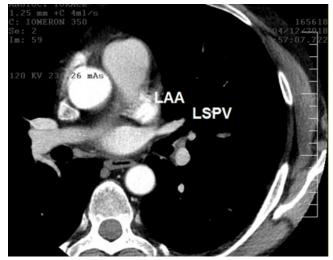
Computed tomography of the heart. The vein that emerges in the same plane with the LAA Is the LSPV. It has an anterior orientation.
